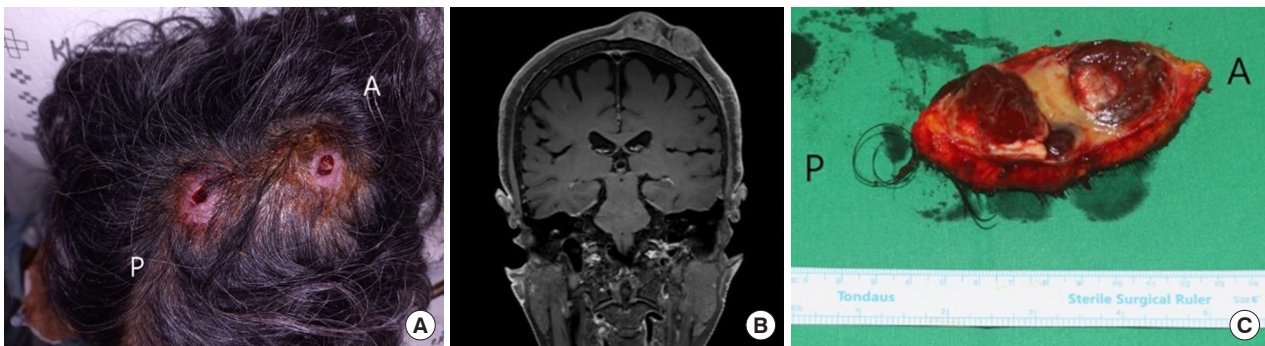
A 77-year-old woman with presumed ruptured epidermal cyst-like masses on the scalp. (A) Incision and drainage of two scalp sites. (B) Facial magnetic resonance imaging showing two suspicious masses of the scalp. Initially, masses were suspected to be ruptured cystic masses but were later revised, considering the possibility of malignancy by a radiologist. (C) An intraoperative photograph of the excised masses. It was widely excised with a 1 cm free margin. Gross photograph showing protrusion into the periosteum. A, anterior; P, posterior.
